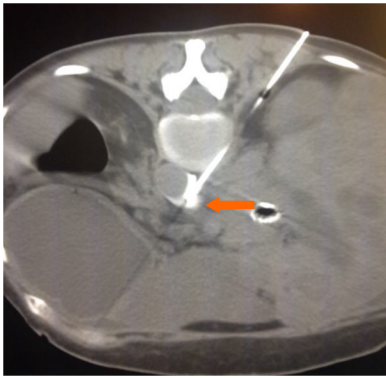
Celiac plexus alcohol neurolysis. In a patient with metastatic pancreatic cancer and non-controlled pain, an 18G Chiba needle (arrow) is inserted under computed tomography-guidance with a paravertebral approach; ethanol (95%–100%) is injected into the antecural space after confirming the needle position with diluted iodinate contrast medium.
